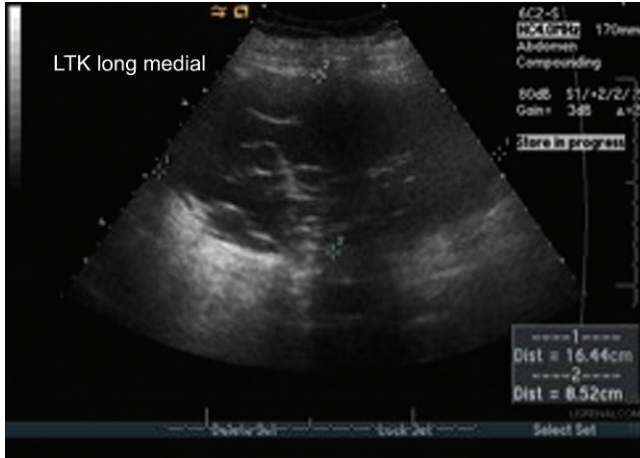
Gray scale sonographic image demonstrates large multicystic left renal mass with echogenic septa. No color flow was identified on color Doppler images within the septa (image not shown).
